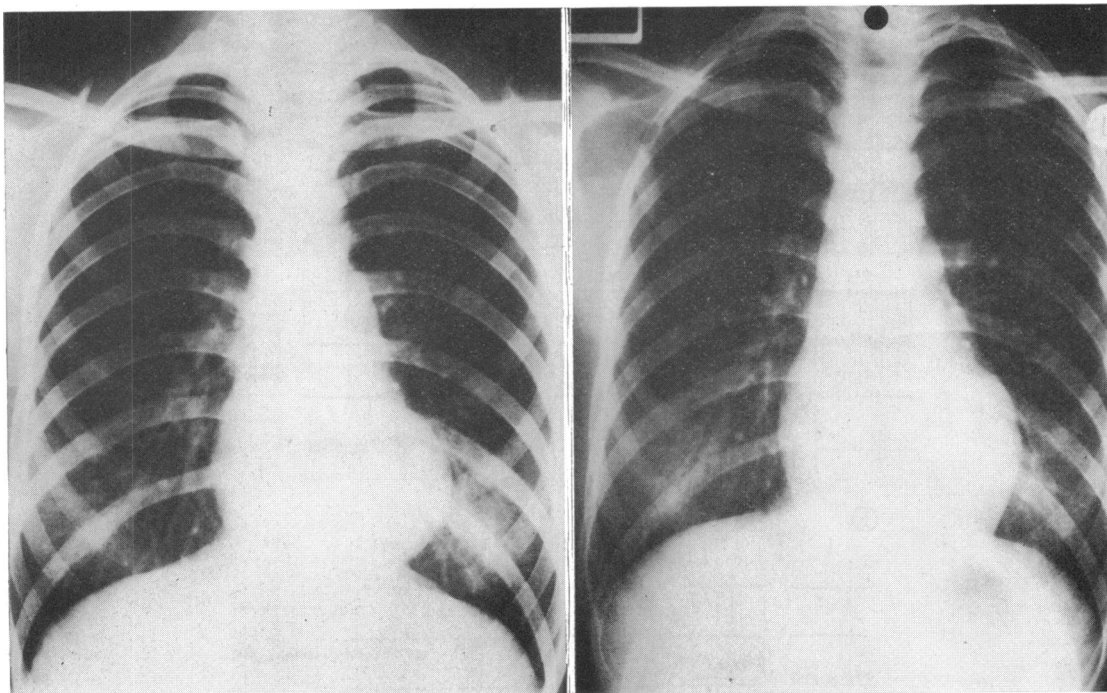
Preoperative (left) and postoperative (right) chest radiographs from Case 2, showing the disappearance of the bulge at the lower left heart border after operation.
